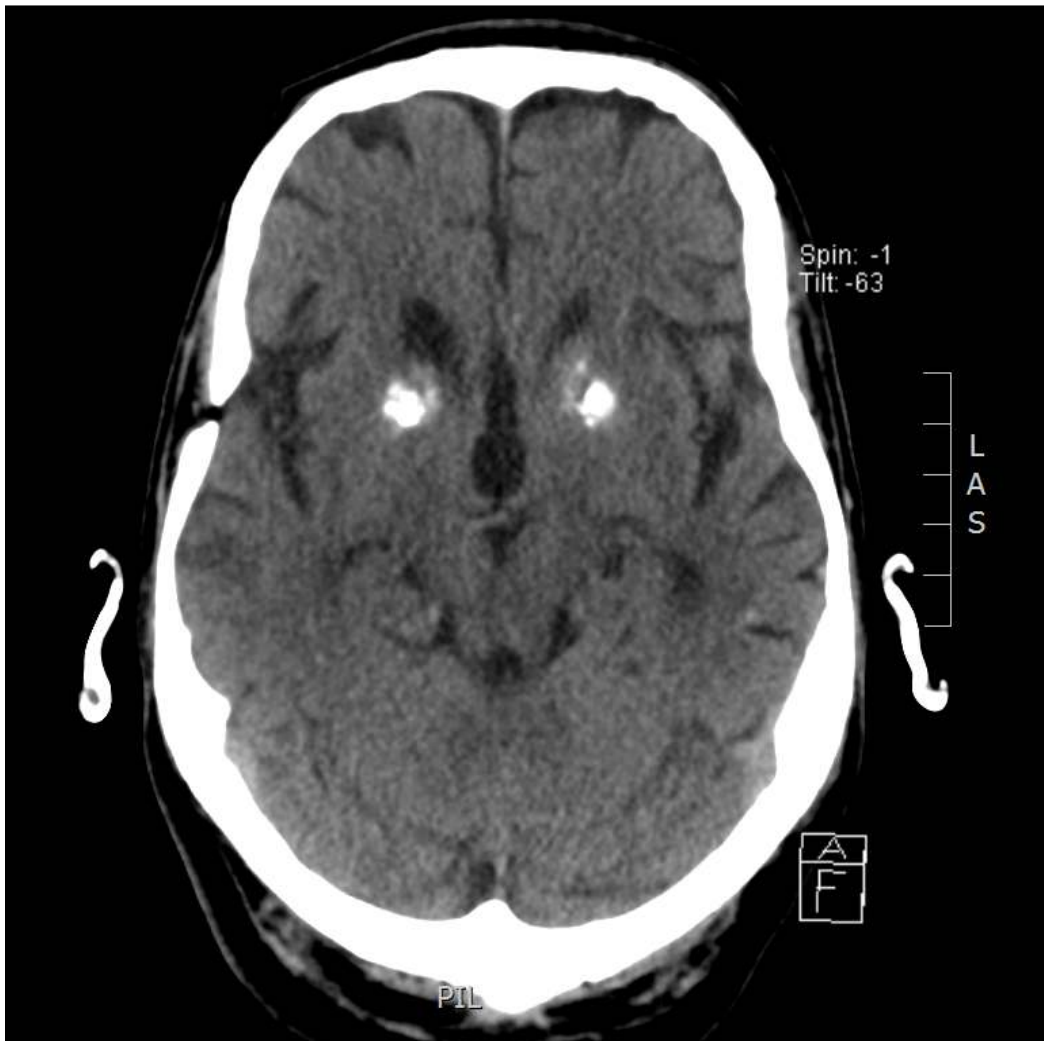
Cranial computed tomography. Profound calcifications of the basal ganglia bilaterally as typically seen in FIBGC or Fahr's syndrome
